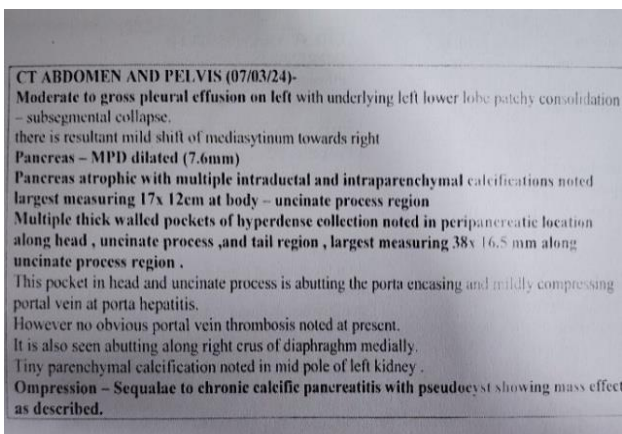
CT abdomen report.
